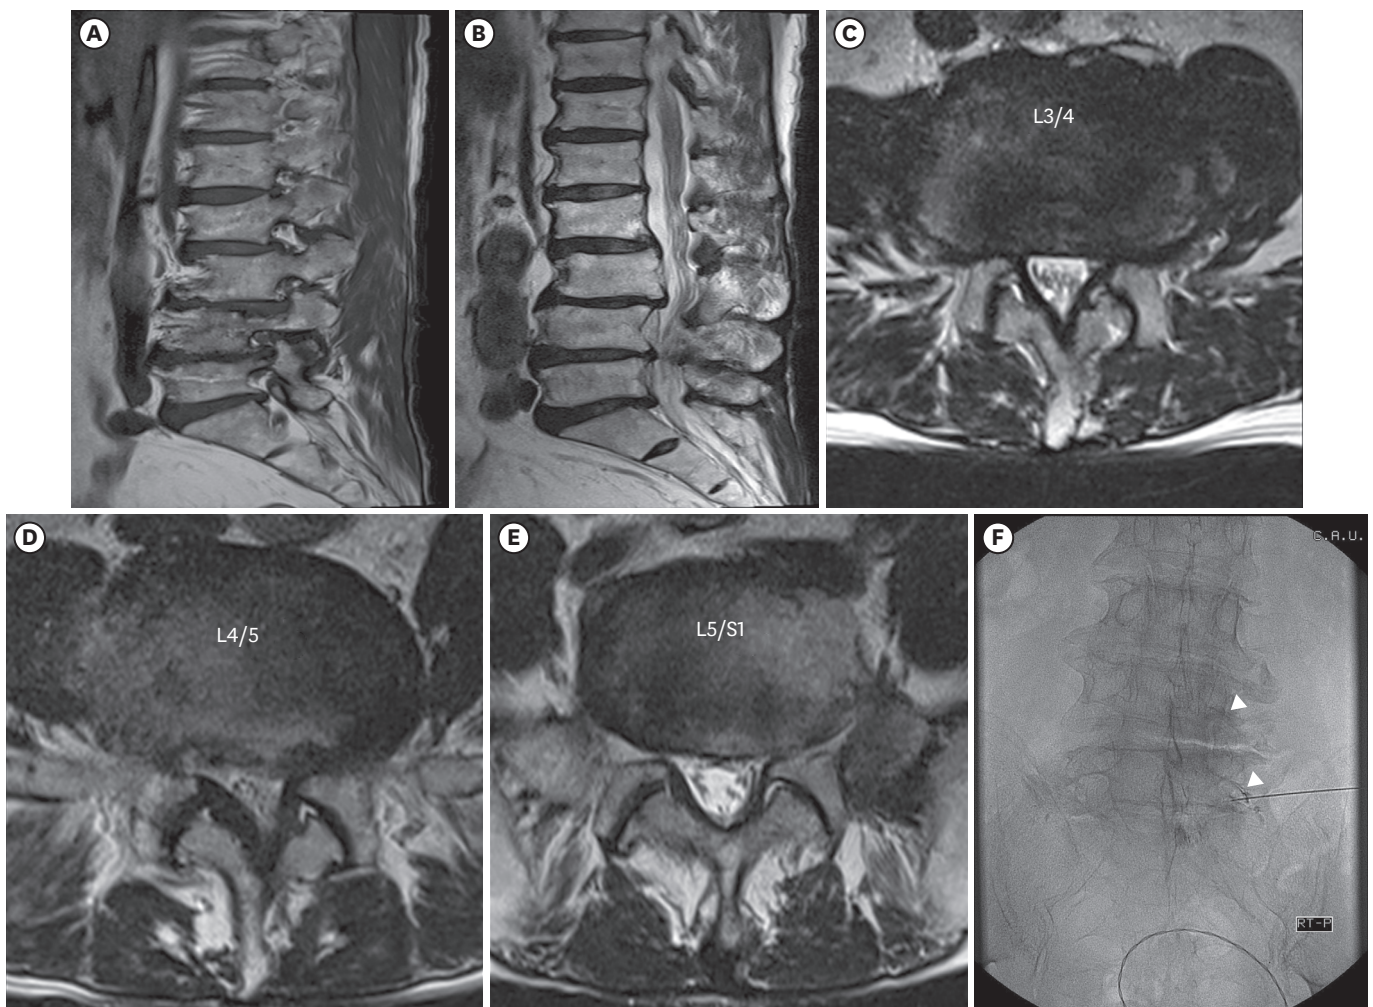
Magnetic resonance images of case. (A) Sagittal section at the right foramen showing multiple foraminal stenosis. (B) Mid sagittal section showing spondylolisthesis at the L3/4 level. Axial sections at (C) L3/4, (D) 4/5, and (E) 5/S1 showing stenosis with facet hypertrophy. (F) Radiograph of radiofrequency sensory stimulation; the right L5 root (lower arrow head) after right L4 root (upper arrow head) stimulation.
